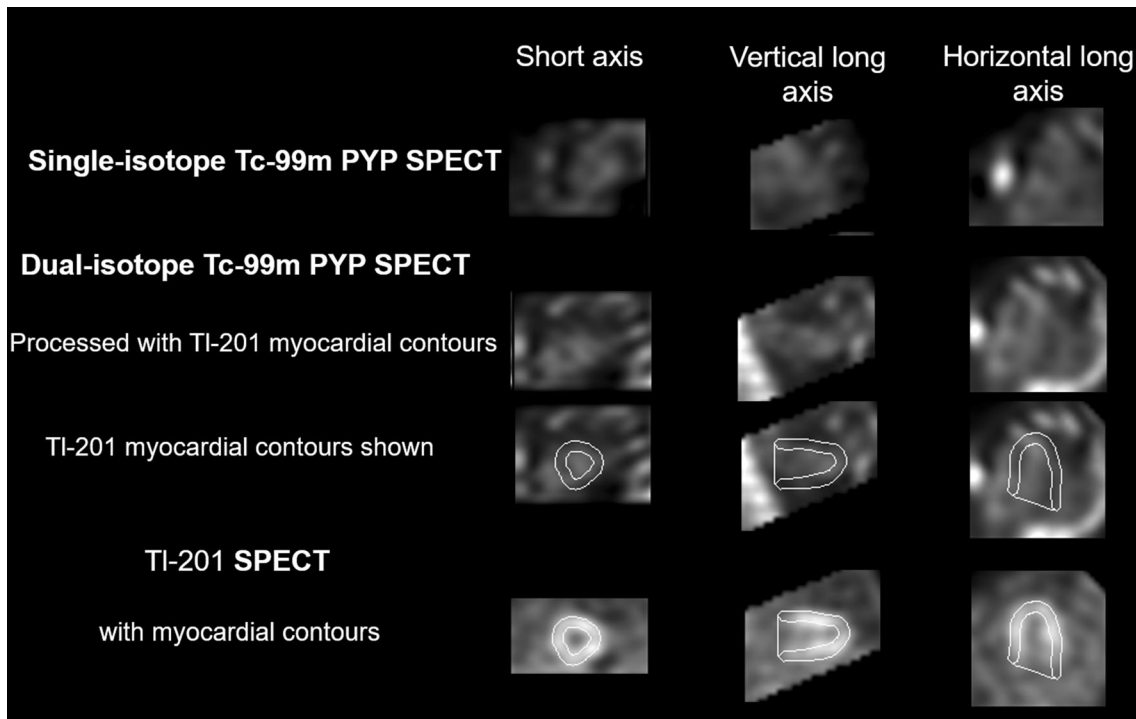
Example of an AL patient with equivocal myocardial Tc-99m PYP uptake with single-isotope method reclassified as normal by simultaneous dual-isotope SPECT. Tc-99m PYP SPECT with single-isotope method processed without knowledge of Tl-201 contours (first row), with knowledge of Tl-201 myocardial uptake from dual-isotope SPECT (second row), overlaid with myocardial contours derived from Tl-201 SPECT (third row) and Tl-201 SPECT with contours (fourth row) from a patient with AL. Regarding myocardial uptake of Tc-99m PYP, the single-isotope images were interpreted as equivocal, whereas the dual-isotope images with superimposed Tl-201 SPECT provide certainty that the Tc-99m PYP is confined to the blood pool.
